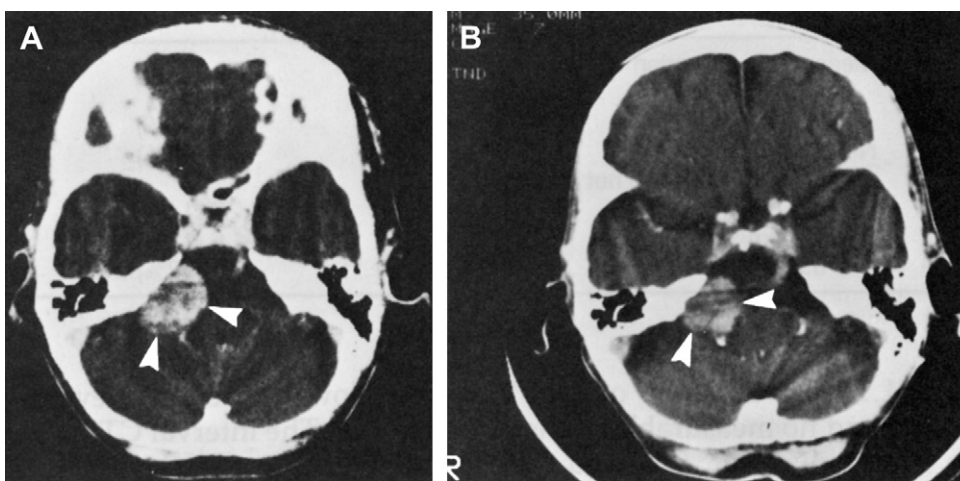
Enhanced axial computed tomography images. Tumor demonstrating no change in size over a 13-year follow-up. (A) Scan from October, 1978; (B) scan from May 1991.
